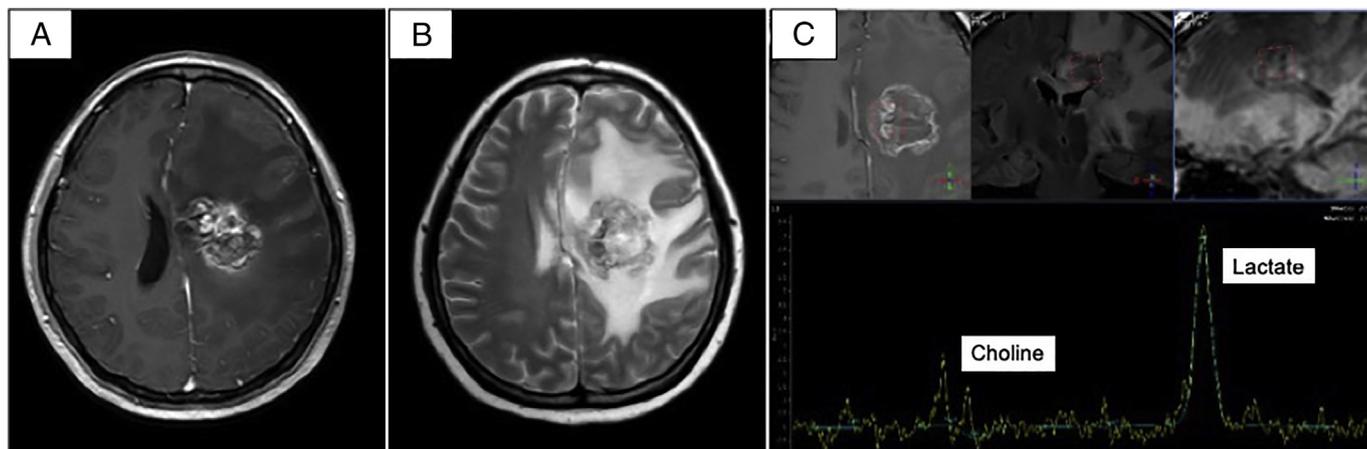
(A) Representative post-contrast T1-weighted image in axial view. There is a heterogeneously enhancing lesion centred in the region of the patient's previous left cAVM. This lesion is associated with local mass effect and midline shift. (B) Representative T2-weighted image in axial view. This image demonstrates the extensive white matter changes secondary to perilesional oedema. (C) Metabolic changes of the MRS show a low choline levels and high lactate peak in the lesion of interest.
